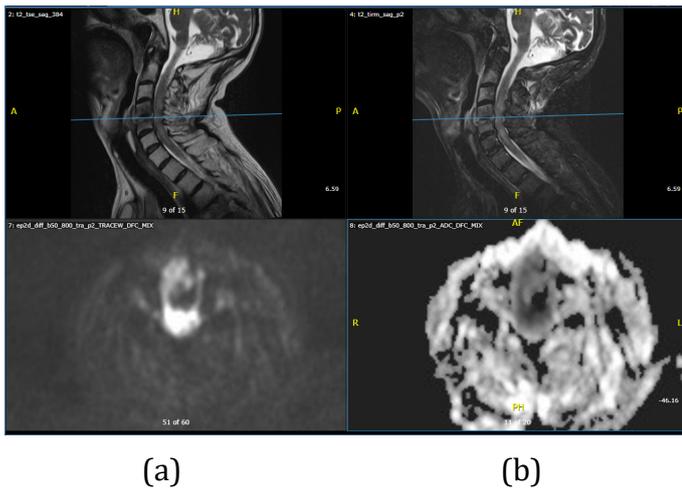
At the level of the most pronounced changes, high signal on DWI (a, low row) and low signal on ADC (b, low row) suggested an infection.
